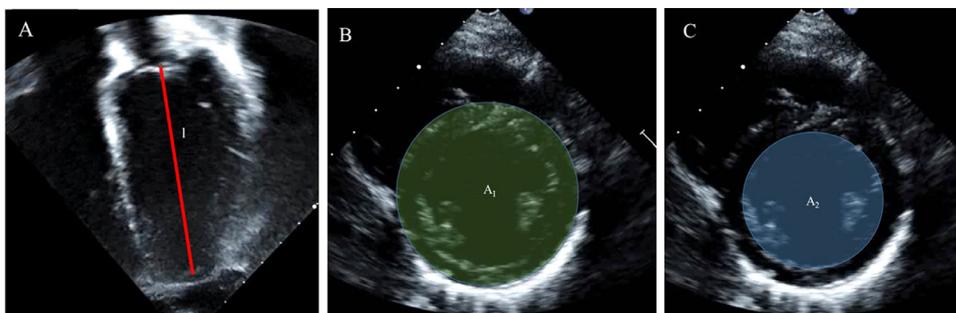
2D volumetric method for LV mass calculation using apical 4 chamber (A) to measure length (l) and parasternal short axis (B and C) to measure the epicardial (A_1) and endocardial (A_2) cross-sectional area.
